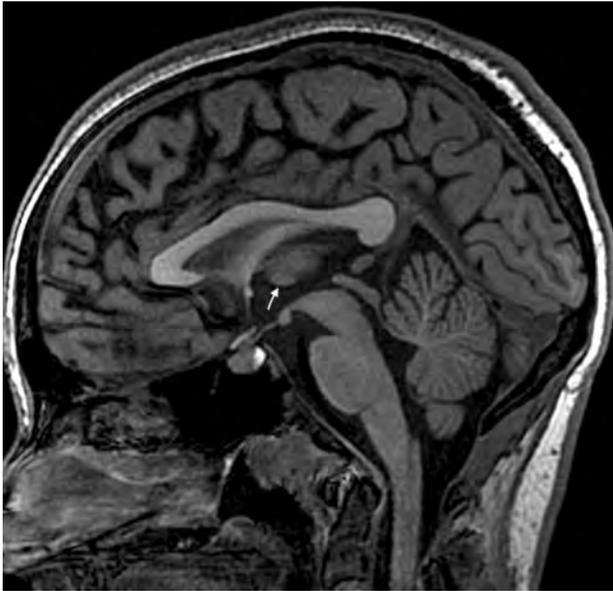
Sagittal midline T1WI from a brain MR imaging with normal findings in a 17-year-old adolescent girl with retroauricular pain depicting the normal thalamic MI centered in the anterior/superior portion of the third ventricle (*arrow*).
